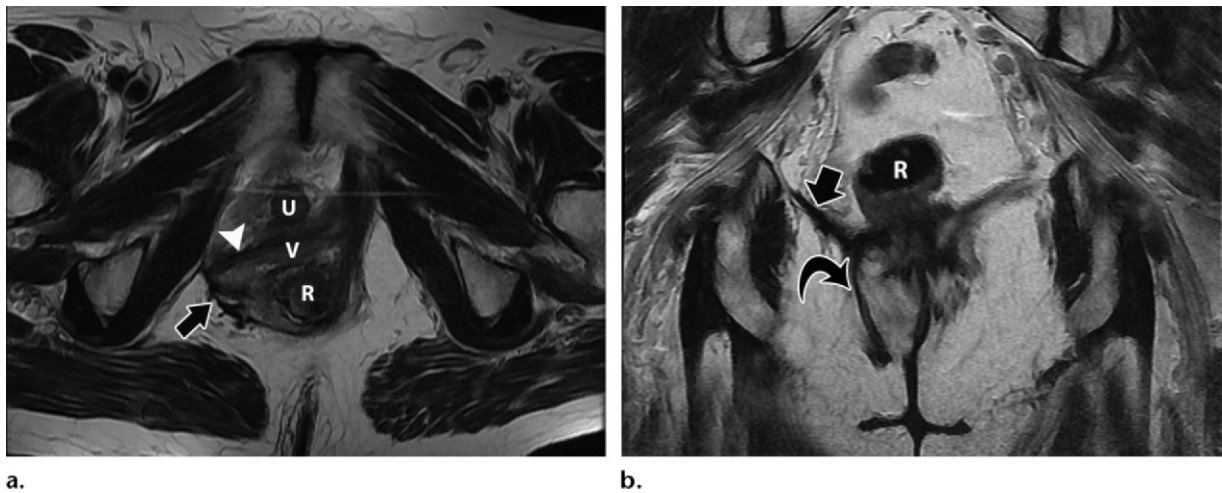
Pelvic muscle defects in a 54-year-old woman with fecal incontinence. (a) Axial T2-weighted MR image shows disruption and fibrosis of the right puborectalis muscle (arrow), distortion of the normal H-like shape and displacement of the right lateral wall (arrowhead) of the vagina (*V*), and poor definition of the urethral ligaments because of disruption. Note the hyperintensity of the right posterolateral aspect of the internal anorectal canal (*R*), an appearance associated with damage to the muscle. *U* = urethra. (b) Coronal T2-weighted MR image shows a tear and fibrosis of the iliococcygeus muscle (straight arrow) with loss of its typical upward convexity. The tear extends through the right ischiorectal fossa (curved arrow). *R* = anorectal canal.
